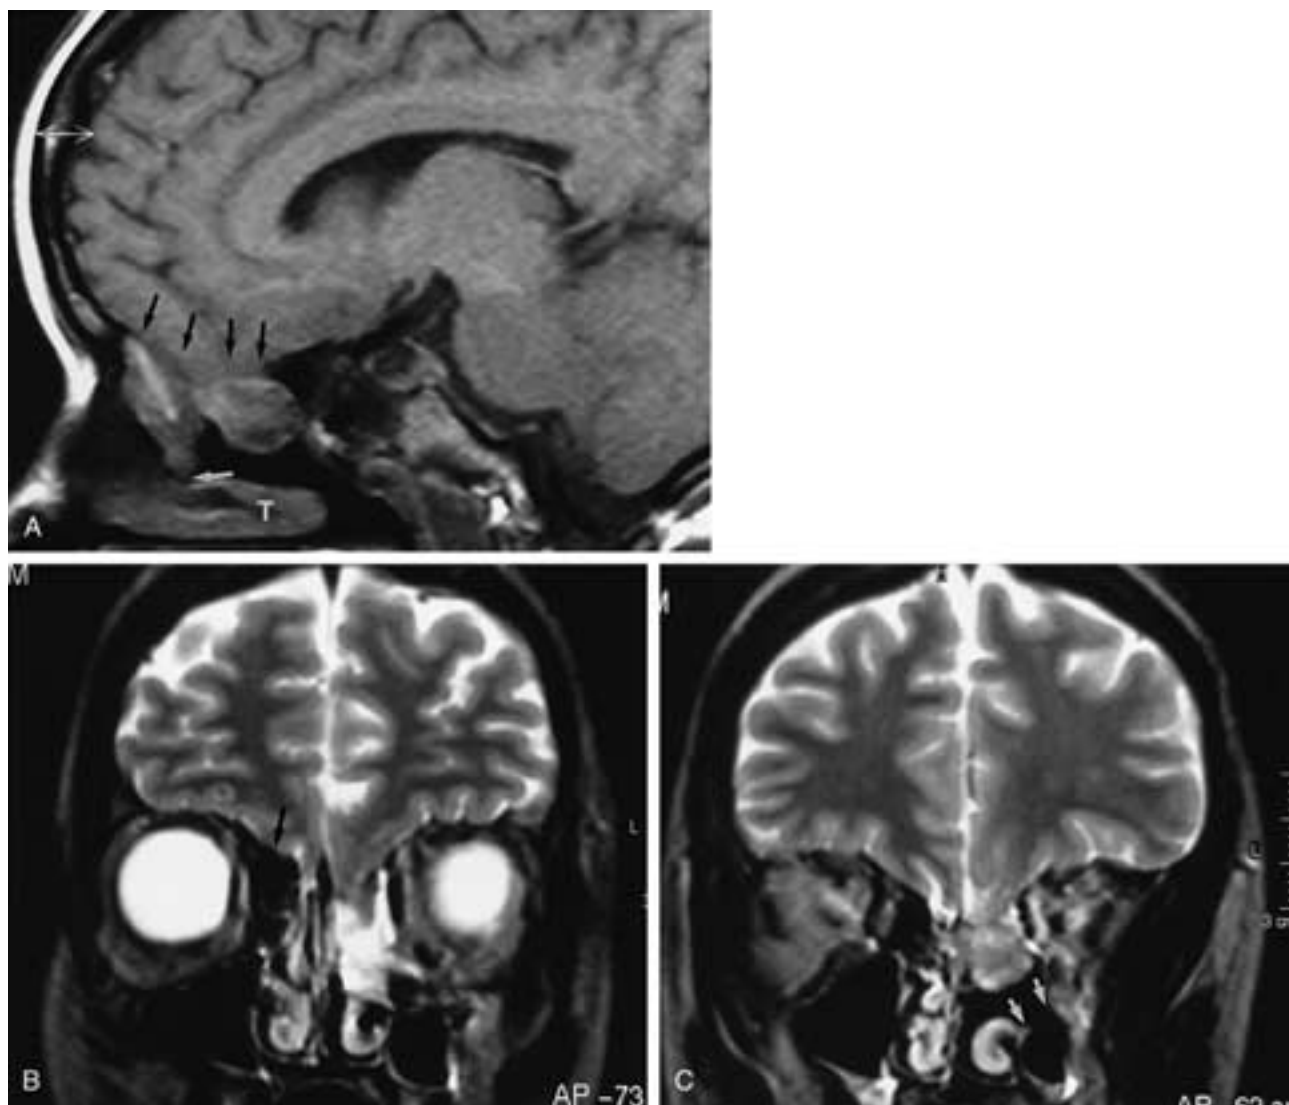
Postoperative meningoencephalocele, left. Nasal obstruction and persistent rhinorrhea was noted 6 months following FESS. A, On this T1-weighted sagittal MR image, note the defect in the anterior skull base (*black arrows*) and the complex large soft-tissue mass in the nasal cavity. The anterior portion of the mass abuts the inferior turbinate (*white arrow*). Inferior turbinate denoted by *T*. B, T2-weighted coronal MR image confirms that the mass is primarily fluid inferiorly, but there is intranasal herniation of the frontal lobe. The intact ethmoid roof on the right is denoted by the arrow. C, T2-weighted coronal MR image posterior to B shows that this portion of the meningoencephalocele is primarily brain tissue. Note the widened maxillary ostium and infundibulum on the left (*arrows*) following surgery and uncinectomy and resection of the left middle turbinate. No surgery had been performed on the right side.
